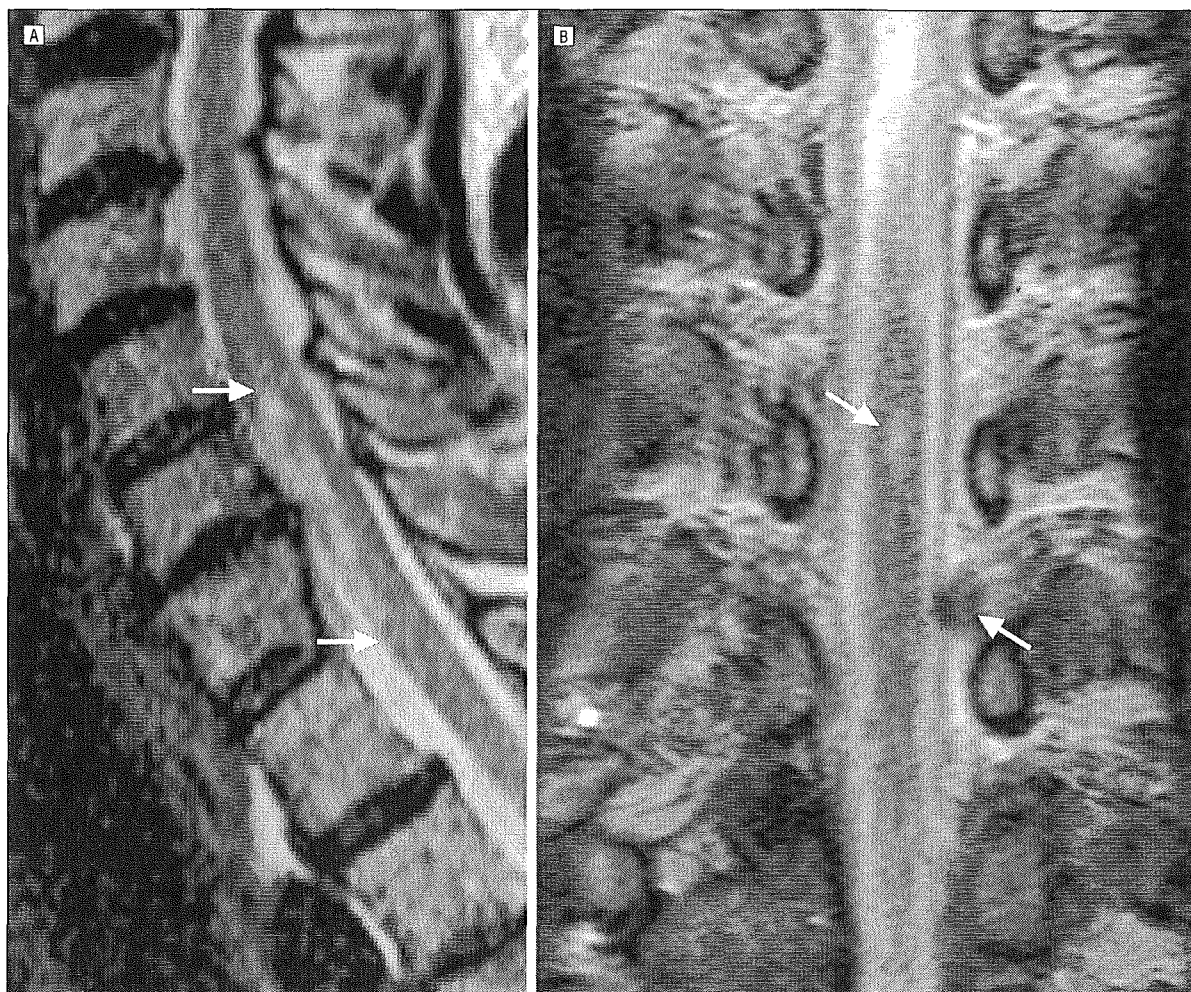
Compression of the radicular artery (anterior spinal artery syndrome caused by a median disk prolapse). A, Sagittal T2-weighted fast spin-echo magnetic resonance imaging sequence (repetition time, 4700 milliseconds; echo time, 112 milliseconds; 3-mm-section thickness; number of signals required, 3; with a 1024×360-pixel matrix) showed a lesion in the territory of the anterior spinal artery. Arrows indicate the extent of the infarct. B, Coronal section of another patient with a lateral herniated disk (right arrow) at the level of the radicular artery corresponding to the cord infarction (left arrow).
